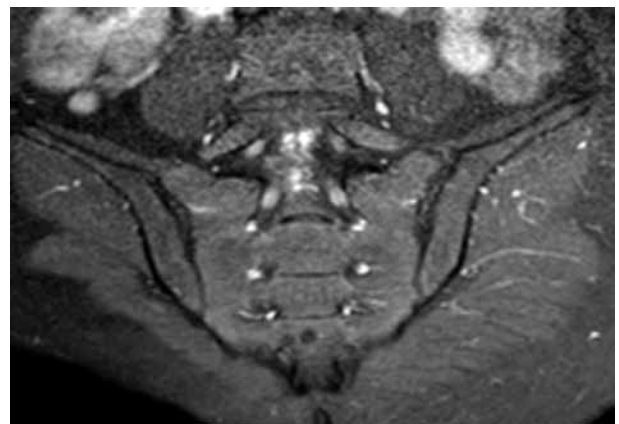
Magnetic resonance imaging findings after discontinuation of drug. Contrast T₁-weighted sequences at the oblique coronal plane reveal normal findings.
